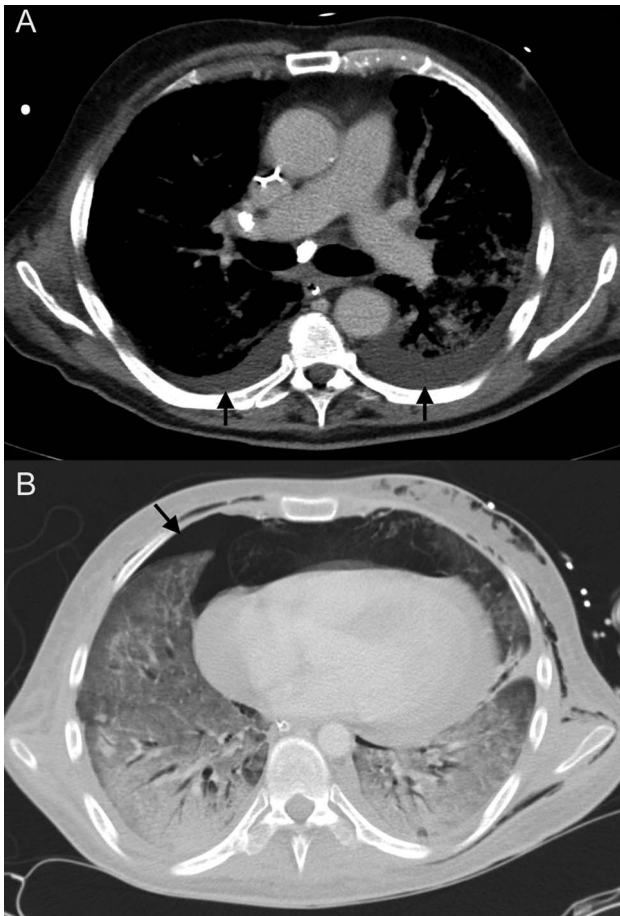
Contrast-enhanced axial computed tomography images of 2 different subjects showing pleural effusion (A) and pneumothorax (B), indicated by arrows.
